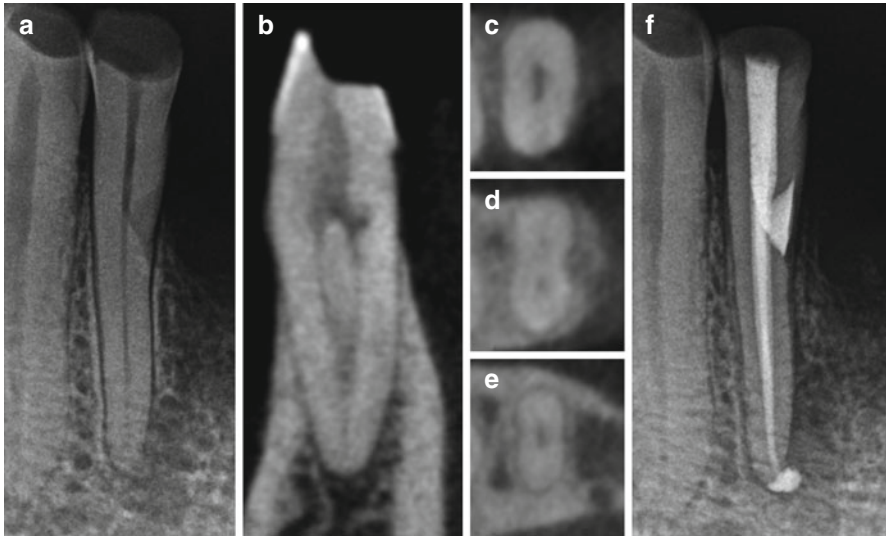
Preoperative periapical radiograph of a left mandibular lateral incisor (note the mid-root resorptive defect) (a) with corresponding sagittal CBCT slice (b) and axial CBCT slices captured from the coronal third (c), mid-root (d), and apical third (e) demonstrating two root canal systems in the coronal third and mid-root, followed by canal confluence in the apical third. Post-endodontic periapical radiograph demonstrates proper management of the root canal system as well as the external repair of the resorptive defect (f)
